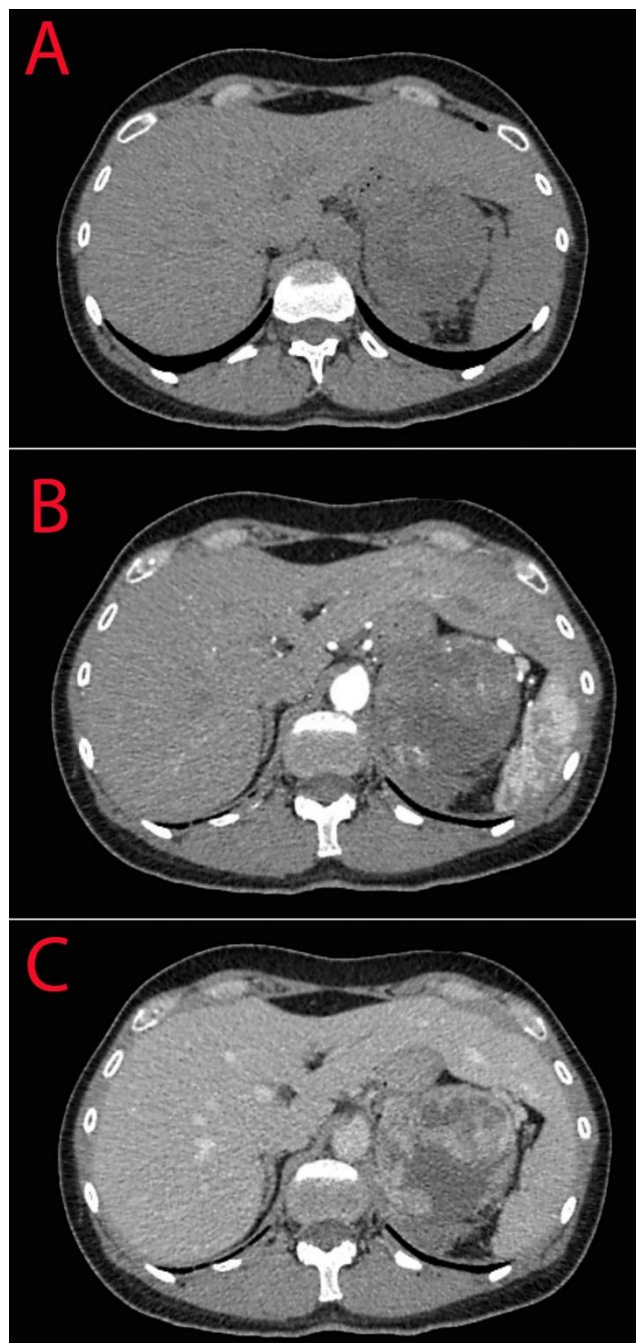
Abdominal CT scan of the patient (the liver can be differentiated from the spleen during the arterial phase). A: Native phase; B: Arterial phase; C: Venous phase.
